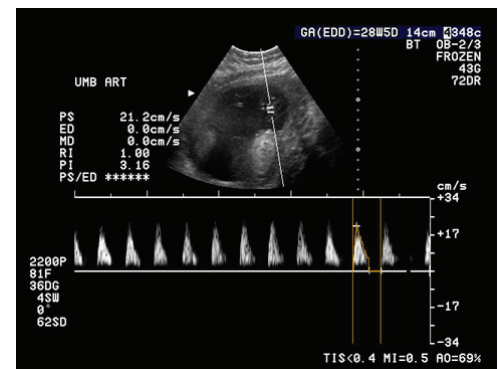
UA Doppler Waveform Patterns
